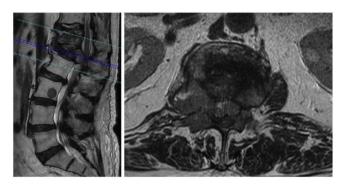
Sagittal (left image) and axial (right image with cut at L1) T2-weighted sequence of dorsolumbar MRI showing metastatic lesions at D12, L1, L3 with compression of the conus medullaris at L1 level by tumour mass anterior to the thecal sac and by pedicle invasion.
